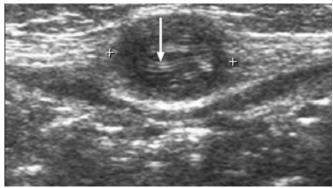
High-resolution ultrasonography image shows linear hyperechoic lesions, i.e. worm (arrow) within the subcutaneous nodule.
